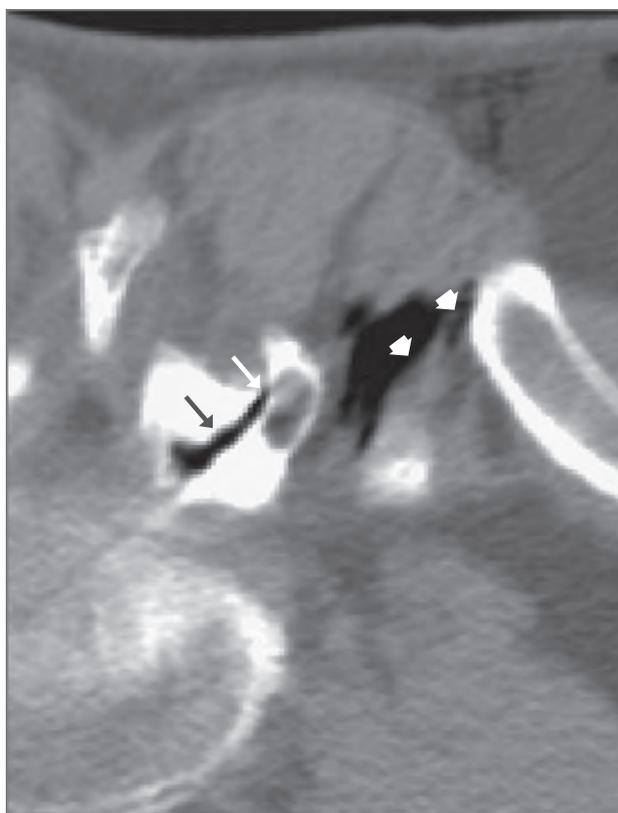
CT scan showing the distribution of the O₂-O₃ gas mixture within the joint (arrows). Once the joint has been infiltrated the ozone is also injected into the muscle to exploit the muscle relaxant action of ozone (arrowheads).
